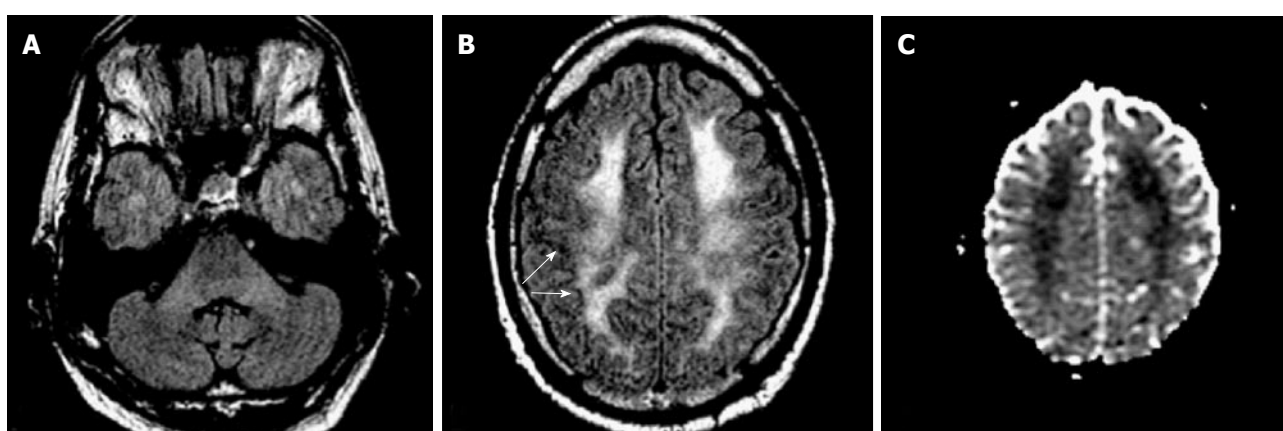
Acute heroin induced leukoencephalopathy (“chasing the dragon”). Twenty-year-old patient found down, history of recent heroin inhalation. A: Axial FLAIR shows subtle increased signal of MCP; Axial FLAIR (B) and ADC maps (C) show concomitant diffuse and confluent increased white matter signal and restricted diffusion with overall sparing of the subcortical u-fibers (arrows on B) and cortex. Though difficult to differentiate from hypoxic-ischemic event, the cortical sparing is more common in toxic leukoencephalopathies. Restricted diffusion has been described not only in the acute stage of toxic heroin inhalation, but in other hypoxic-toxic-metabolic states and could represent acute intramyelinic or excitotoxic edema, in some cases reversible. Evolution could lead to a chronic “chasing the dragon”, spongiform leukoencephalopathy, where the posterior white matter, pons and MCP are typically involved. MCP: Middle cerebellar peduncles.
